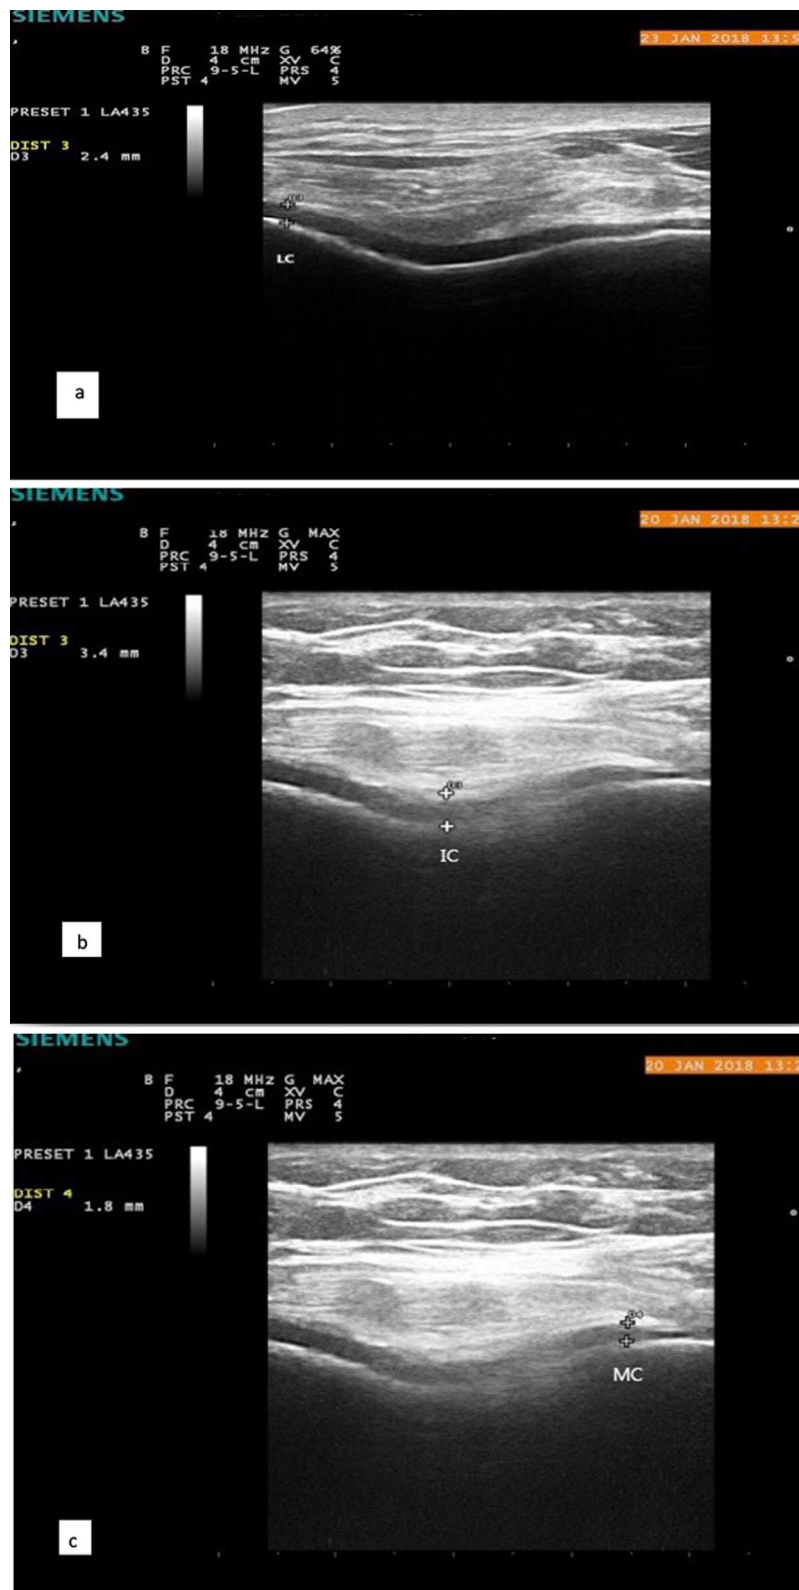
B-mode ultrasound transverse scan of the anterior knee joint in male patient aged 29 years showing thickness of femoral cartilage at a lateral condyle=2.4 mm, b intercondylar area=3.4 mm, and c medial condyle=1.8 mm
